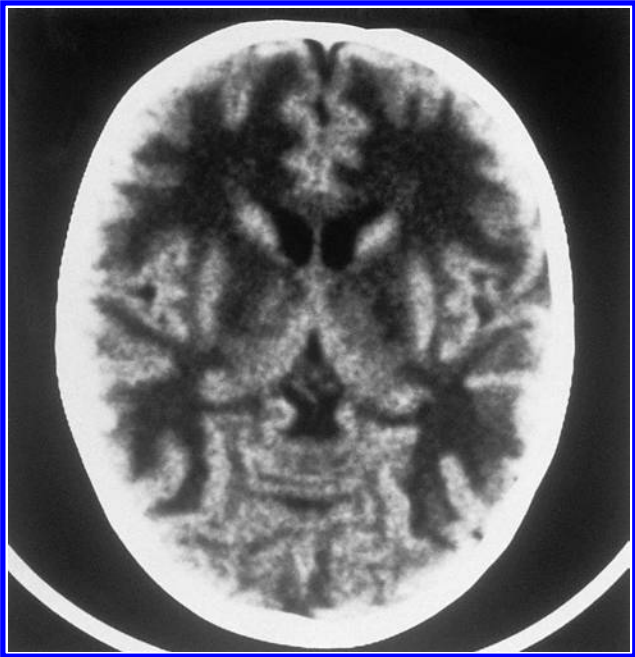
Computed tomography scan of the brain revealed diffuse symmetrical disease of the white matter.
